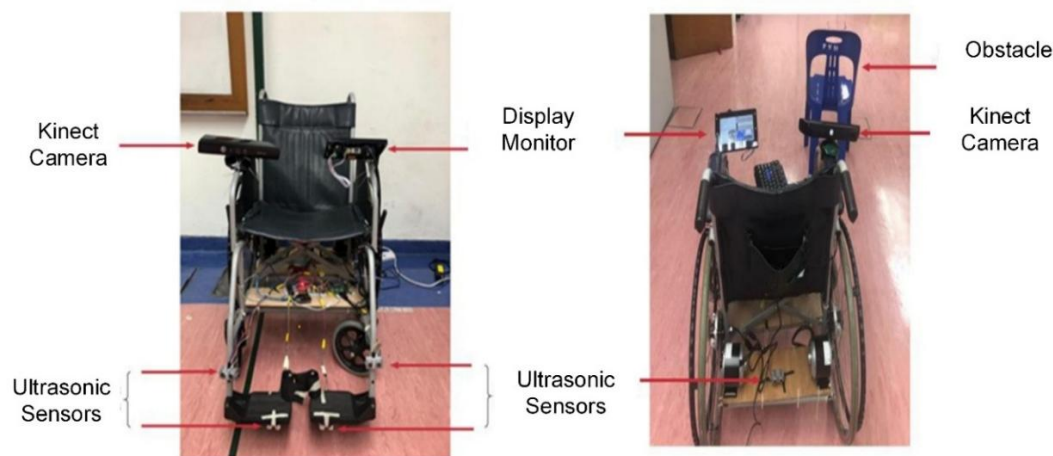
Front and back views of placing the ultrasonic sensors on the wheelchair [28]
